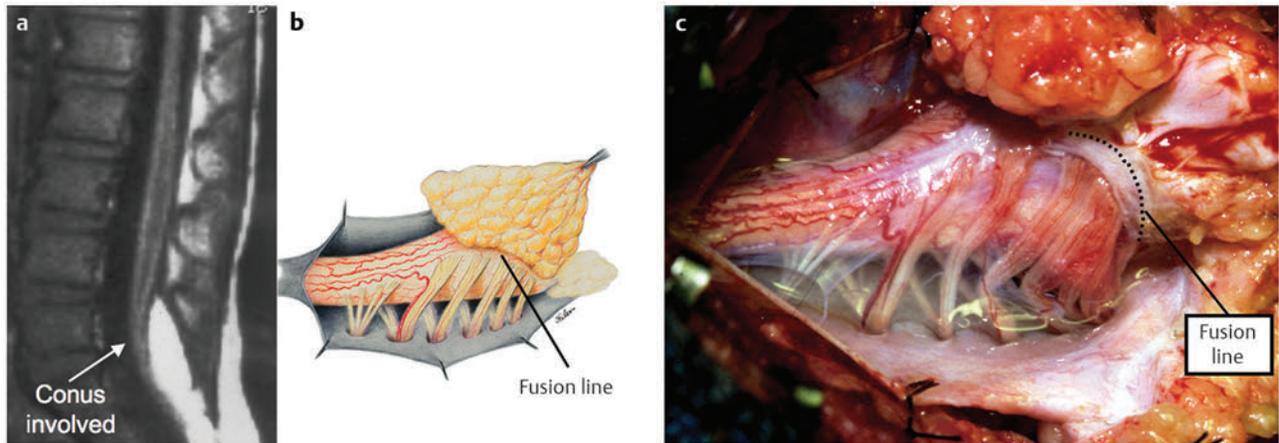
Transitional lipoma. (a) Sagittal magnetic resonance image shows that lipoma begins dorsally but involves the entire conus. The ventral side of the neural placode is free of fat. (b) The plane of the fusion line begins dorsally, then cuts obliquely toward the tip of the conus. The array of DREZ and dorsal roots is also forced to slant dorsoventrally. (c) Intraoperative picture showing a massive lipoma but a very distinct dorsoventral fusion line separating fat from the DREZ and dorsal roots, which always lie lateral and ventral to the fusion line. The ventral side of the placode is always free of fat in a regular transitional lipoma
